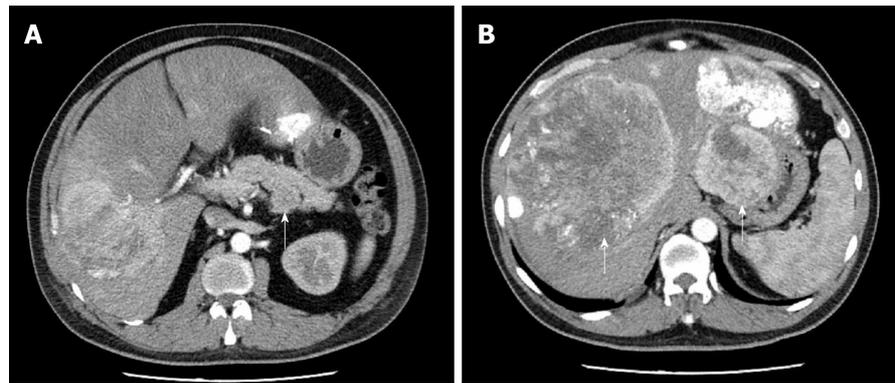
Computed tomography imaging of the abdomen. A: A 4.7 cm × 4.4 cm mass (white arrow) located in the body of pancreas. Non-uniform enhancement was observed from the arterial phase [computed tomography (CT) value = 68 Hu] to portal venous phase (CT value = 59 Hu); B: Numerous liver metastatic tumors (white arrows). Enhanced scanning showed irregular enhancement and the largest one located in segment VIII measured 15.9 cm.
